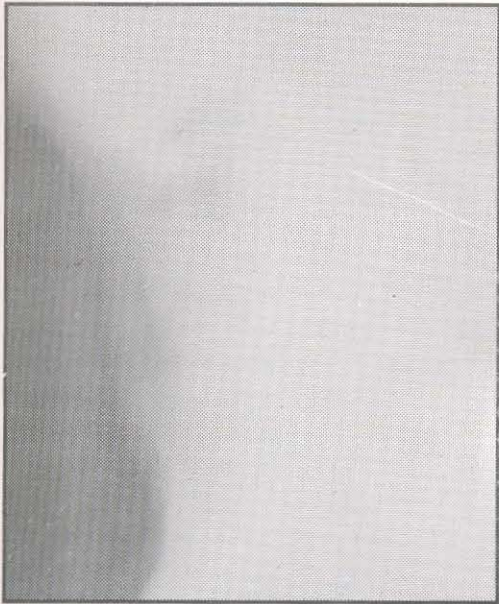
X-ray soft tissue neck (lateral view) showing triangular shape radiodense foreign body in the laryngeal airway.
